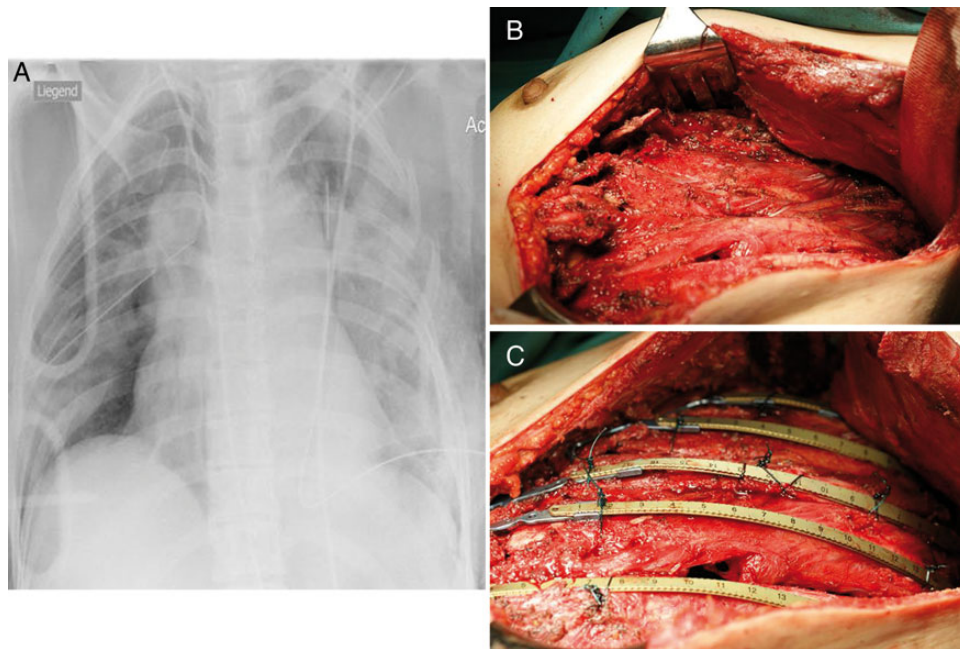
(A) Chest X-ray after a severe blunt chest trauma showing bilateral dislocated rib fractures and a left haemothorax. An extended flail chest was diagnosed on the left side. (B) Intraoperative situs with severe dislocated rib fractures and impaction of the unstable segment. (C) Left chest wall after stabilization showing the rib clips and the connecting bars. The chest wall is well-shaped, avoiding postoperative restriction.
